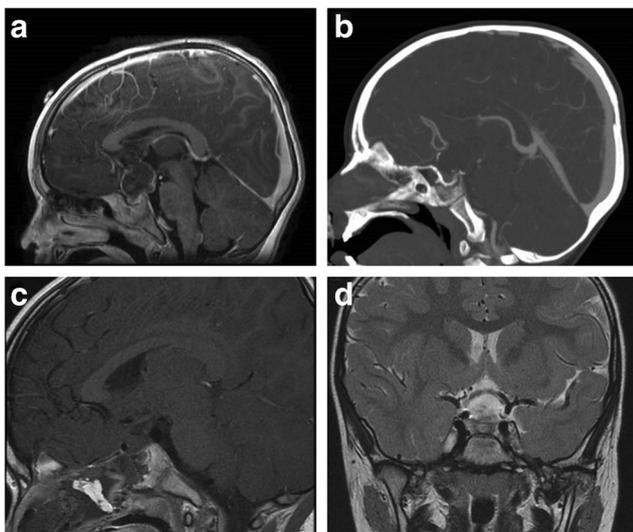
a Preoperative sagittal contrast-enhanced MR image of 2-year-old patient with a suprasellar cystic craniopharyngioma. b Preoperative shows two calcifications in craniopharyngioma as well as non-aerated sinuses. c Postoperative sagittal view of same patient showing pedicle of endonasal flap, fat packing of nose, and GTR of lesion. d Postoperative coronal view of same patient showing pedicle of endonasal flap, fat packing of nose, and GTR of lesion
